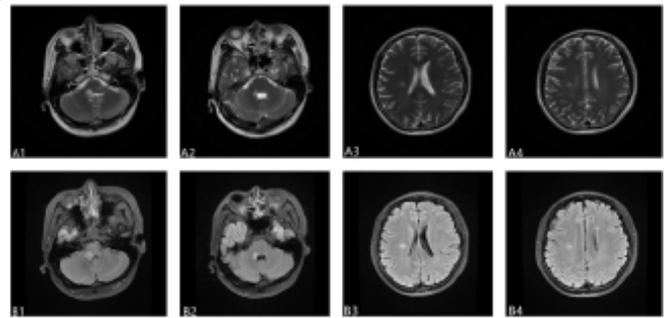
Brain MRI revealed lesions of hyperintense on T2-weighted(A1-A4) and FLAIR (C1-C4) images in the brainstem and the right corona radiata(B1-B4).
